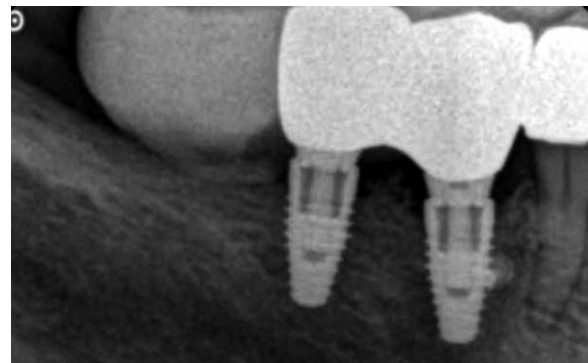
Periapical radiograph taken 1-year after loading.
